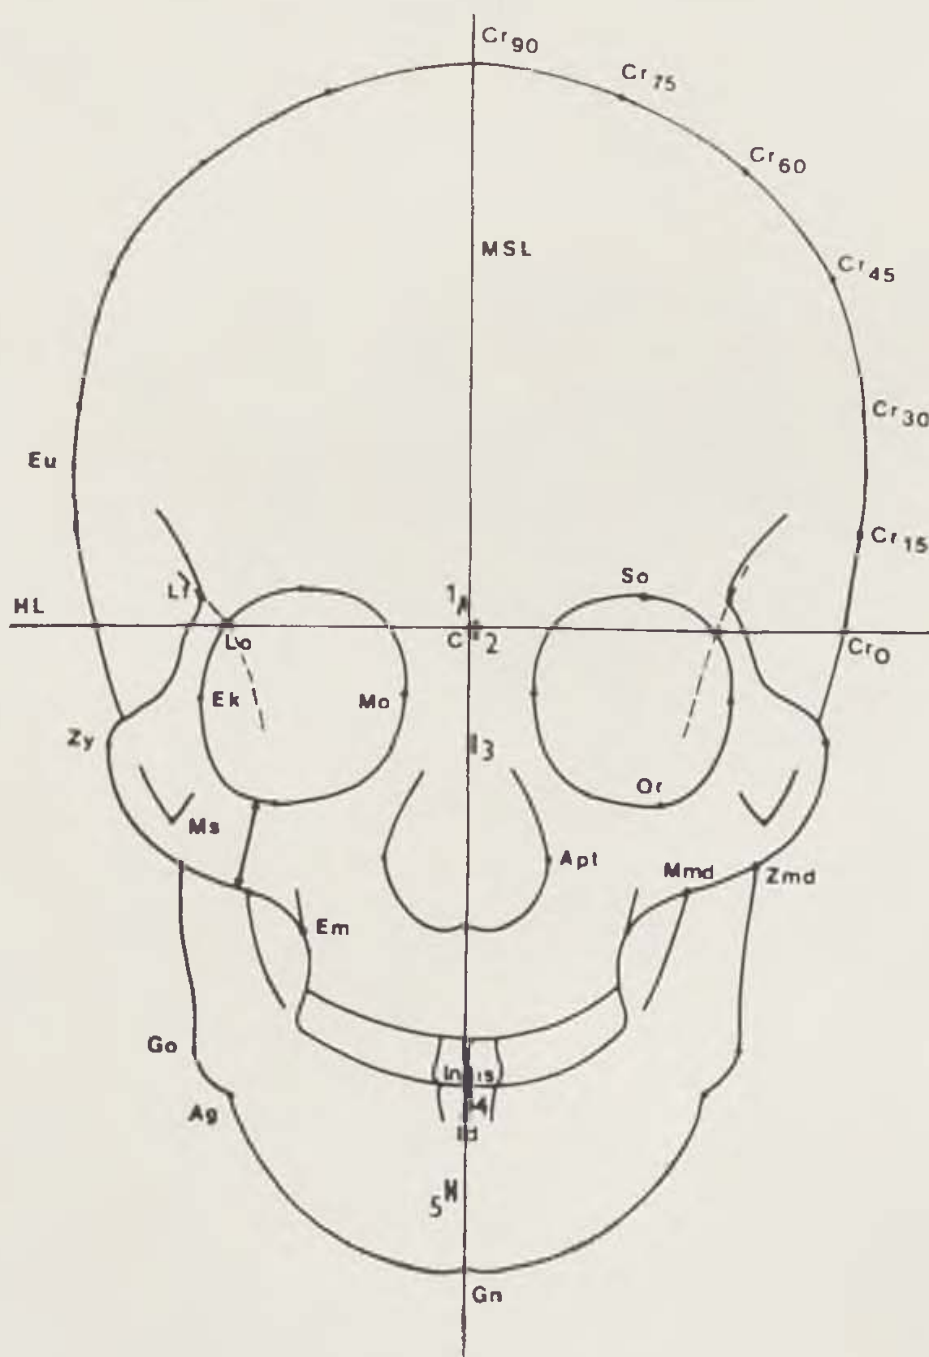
Cephalometric points on anteroposterior X-ray films and the method of construction of mediosagittal line (see text).
